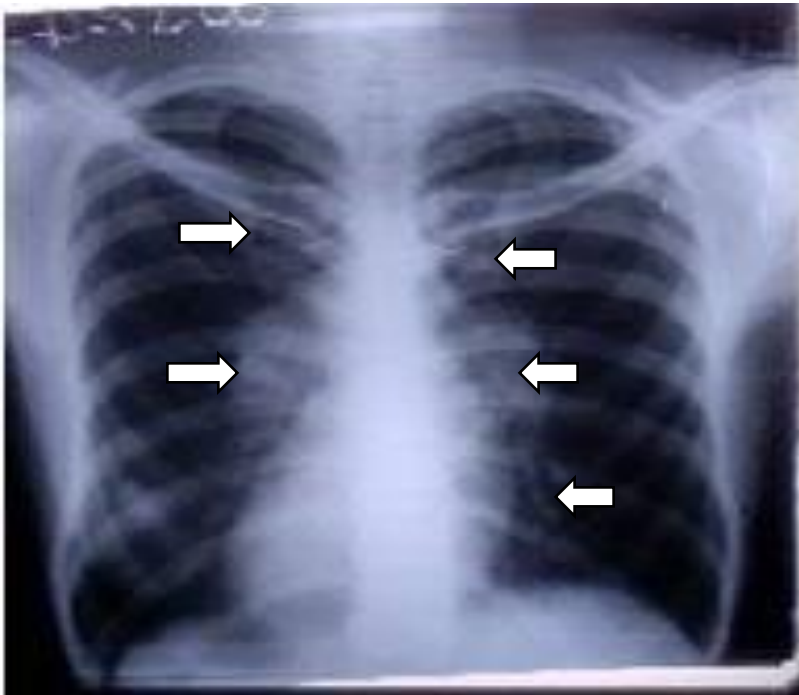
Antero-posterior radiograph of Chest showing prominent hilar marking and a nodule in the lower right chest suggestive of cannon balls
